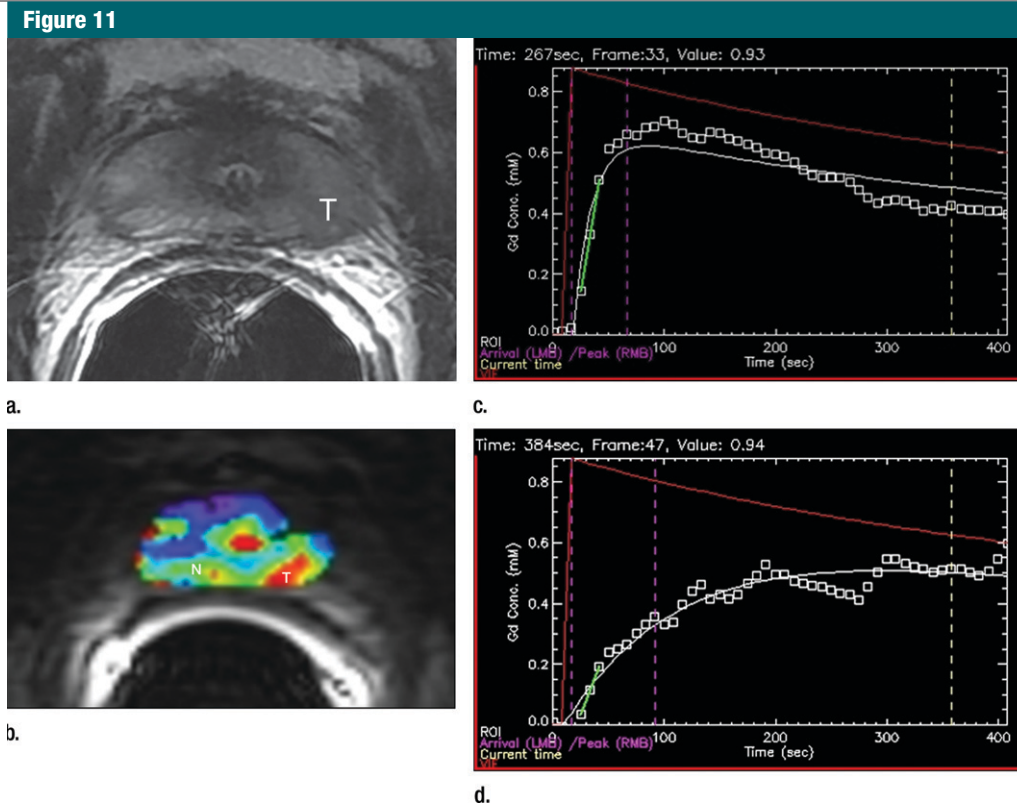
Biopsy-confirmed prostate cancer recurrence in left peripheral zone in 72-year-old patient after external-beam RT. (a) Transverse T2-weighted MR image shows area suspicious for tumor recurrence (*T*), but the possibility of normal post-treatment change cannot be excluded. (b) K^{trans} map from axial dynamic contrast-enhanced MR imaging shows increased enhancement in area suspicious for tumor recurrence (*T*), compared with area of normal prostate tissue (*N*). (c, d) Contrast enhancement–time curves generated from dynamic contrast-enhanced MR imaging data show rapid avid enhancement in (c) region suspicious for tumor, as compared with (d) normal prostate tissue.
